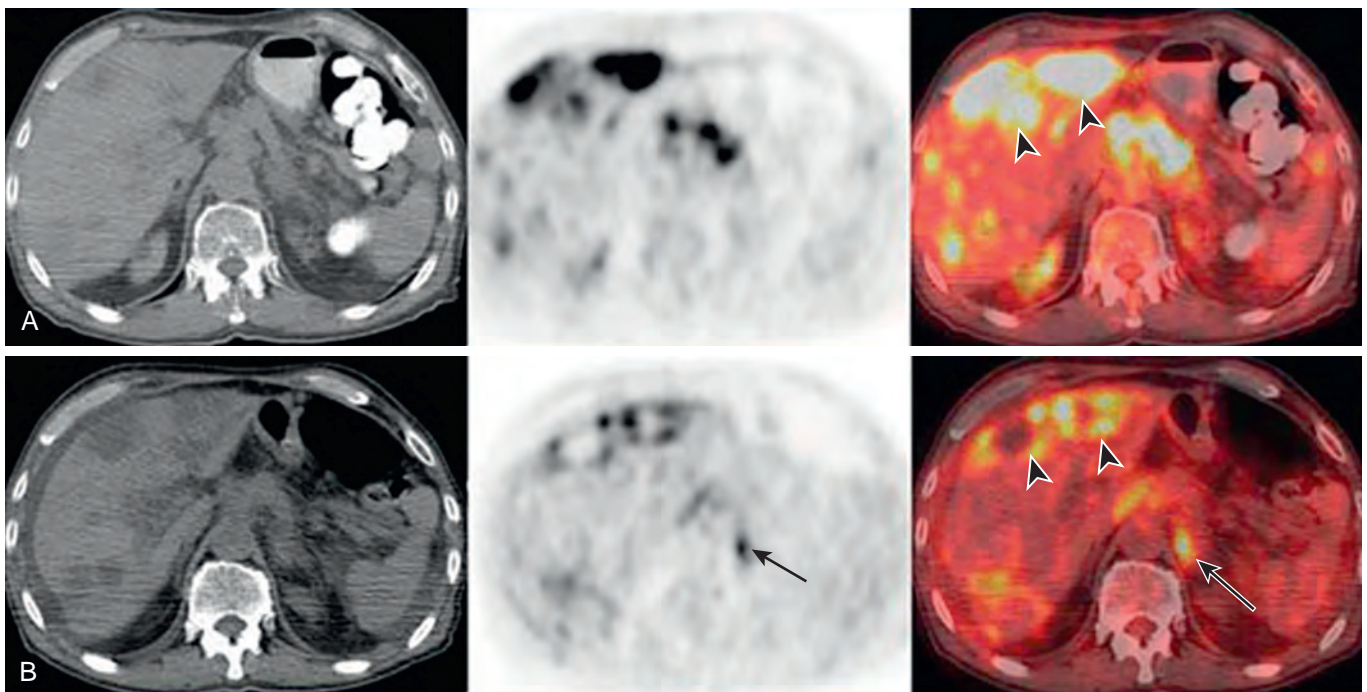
PERCIST criteria. A 53-year-old with colorectal cancer metastases undergoing combined chemotherapy with gemcitabine and irinotecan. Pretreatment (A) and post-treatment (B) PET/CT image sets showed 50% decrease in SUL in previously seen hepatic metastasis (arrowheads). However, a new hypermetabolic retroperitoneal lesion (arrows) was seen on image B, indicating progressive disease.
